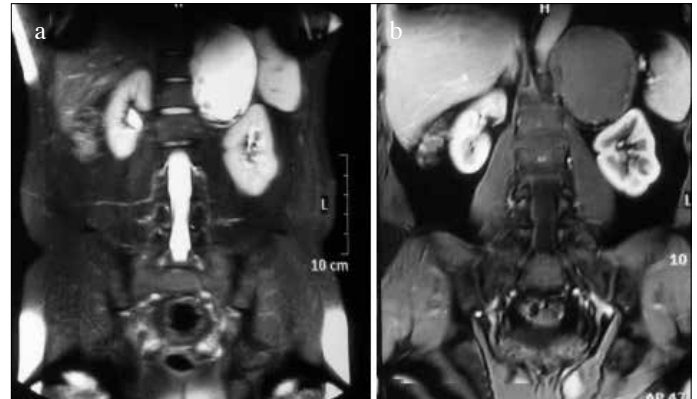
a, b. (a) T2 weighted MRI image showing left adrenal cyst. (b) After gadolinium contrast administration cyst showing mild enhancement
